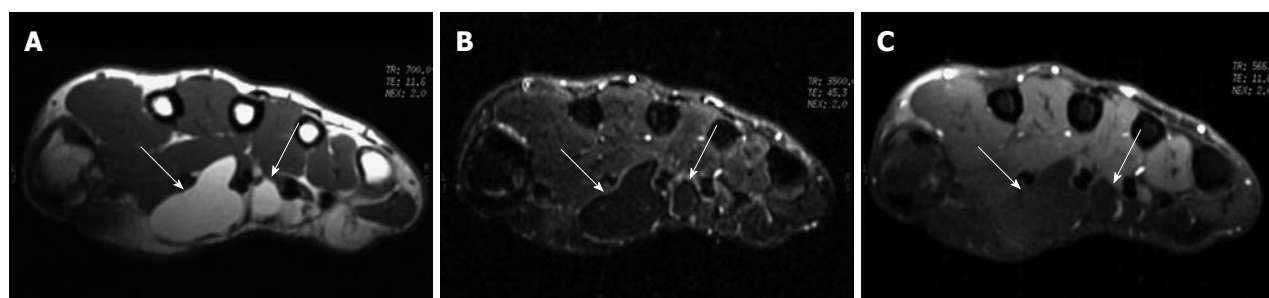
Lipoma of the tendon sheath. A: T1-weighted MR image of the right wrist shows a lobulated high-signal-intensity mass (arrows) located between the palmar muscles; B: Fat-saturated proton-density weighted MR image shows homogeneous low signal intensity of the tumor mass (arrows), suggestive of a fat component; C: There is no enhancement of the tumor mass (arrows) after gadolinium administration on fat-saturated T1-weighted image. MR: Magnetic resonance.
